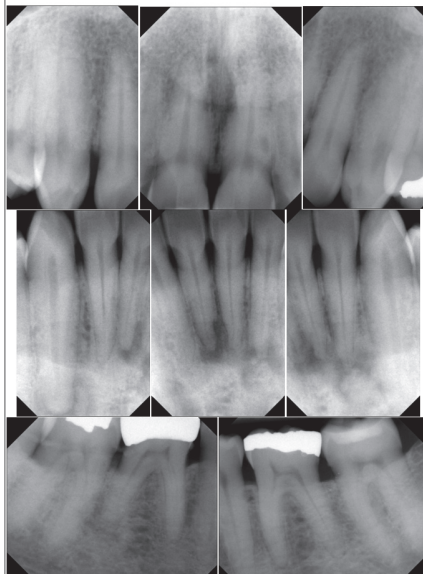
Case 2 - Periapical Radiographs
